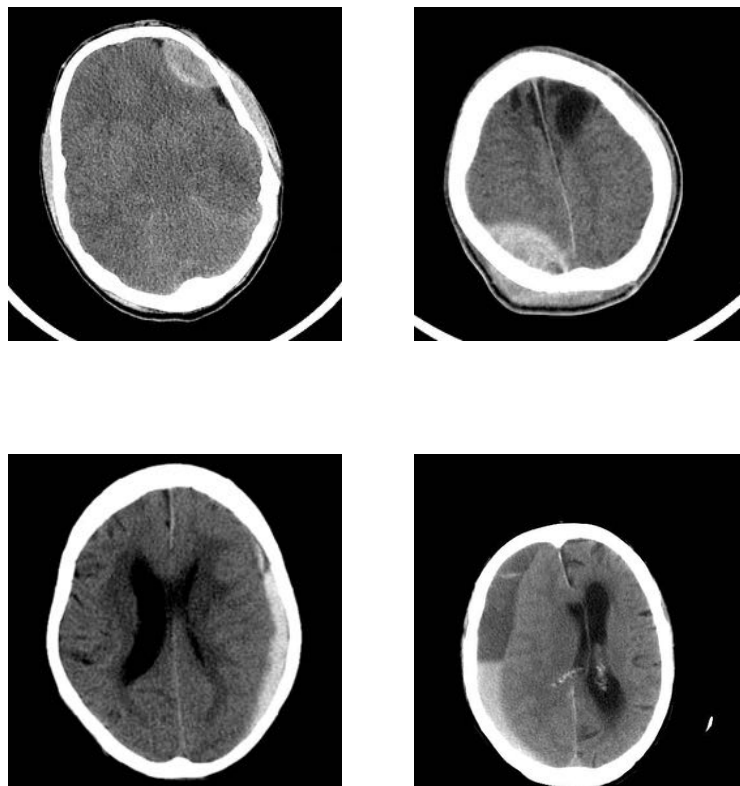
Intracranial haematomas, as seen on noncontrast brain CT scans. Images in top row show the lenticular presentation of EDH. Images in the bottom row present the crescent shaped SDH.
